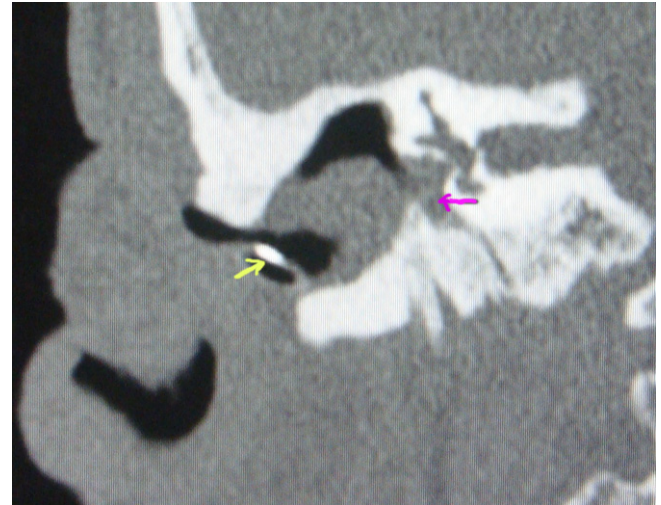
High resolution computed tomography (HRCT) of the temporal bone (coronal section at the level of the oval window). The image demonstrates a cannulated fistulous tract (yellow arrow) communicating with the middle ear cavity occupied by a soft tissue mass causing smooth lining of the mesotympanum and hypotympanum with erosion of scutum. The ossicular chain is not visualized. The bony canal of the tympanic (horizontal) segment of the facial nerve shows erosion in its inferior aspect (pink arrow).
